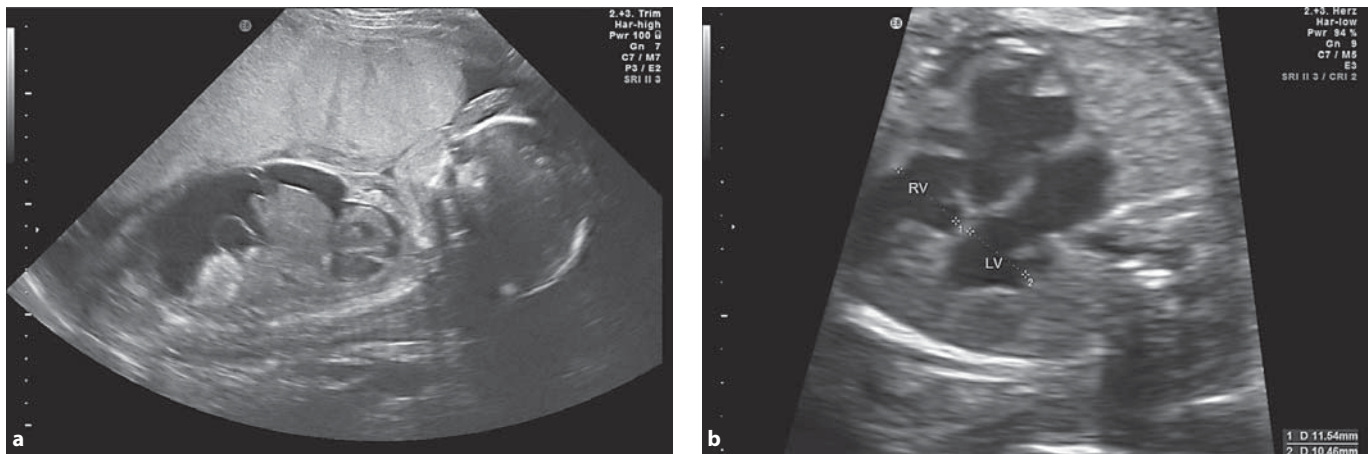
a Ultrasonographic findings at 26 weeks 0 days of gestation of the placental edema; fetal hydrops with ascites and subcutaneous edema, pronounced at the forehead. b Ultrasonographic findings of the fetal echocardiography: cardiomegaly with biventricular myocardial hypertrophy; displacement of the tricuspid valve towards the apex of the right ventricle. RV = Right ventricle, LV = left ventricle.
